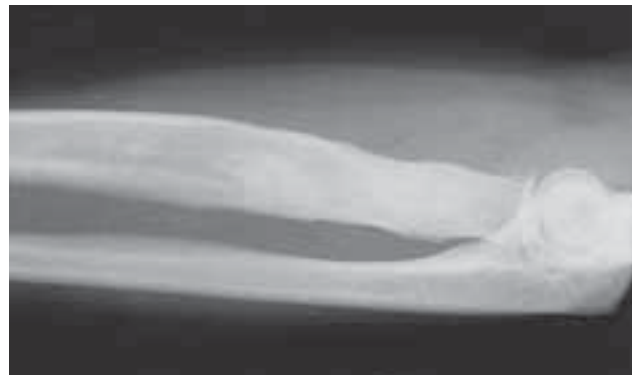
This patient presented with a partial posterior interosseous nerve palsy. Plain films showed thickened cortices and a widened radial metaphysis, bony changes from an old osteomyelitis. (From Spinner, R. J., and Spinner, M.: Tardy posterior interosseous nerve palsy due to childhood osteomyelitis: A case report. *J. Hand Surg.* 22A:1049, 1997.)
